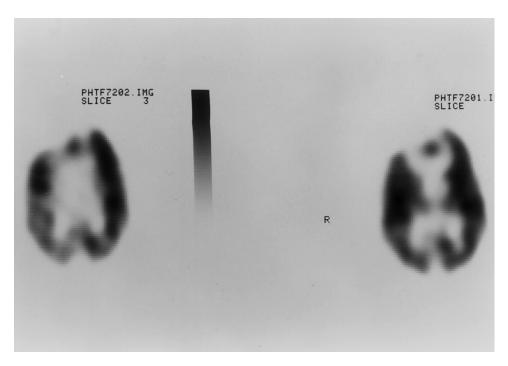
FDG PET scan of a head injury patient demonstrating significant hypometabolism in the right frontal lobe as well as diffuse hypometabolism throughout the posterior cortical areas consistent with diffuse axonal injury. (Reprinted with permission from Newberg A, Alavi A: Neuroimaging in patients with head trauma, Nucl Med Ann, 1996, pp 195-212).
